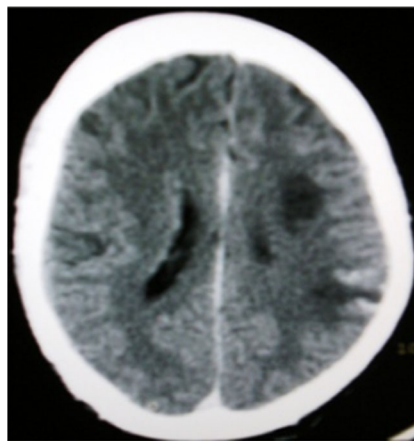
CT film of brain abscess
